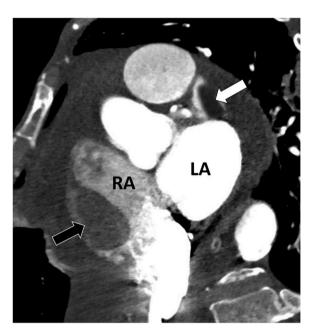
CCTA of a 66-year-old woman with atrial fibrillation and post central line removal. She was referred for CCTA to evaluate coronary artery disease. Incidental found thrombus in left atrial appendage (white arrow) and right atrium (black arrow) were demonstrated. (CCTA: Cardiac computed tomography angiography, RA: Right atrium, LA: Left atrium).
